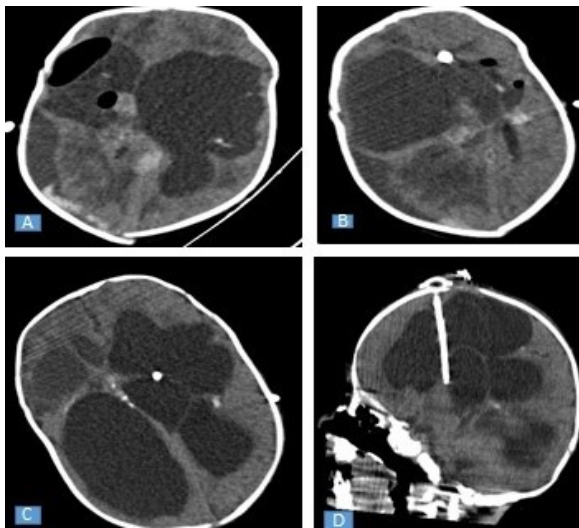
A: Demonstration of multiloculated hydrocephalus of 0-aged male baby on axial brain CT. B, C: Axial brain CT showing external catheter placed in the lateral ventricle and cyst. D: Electively placed VP shunt catheter is observed on sagittal brain CT.
